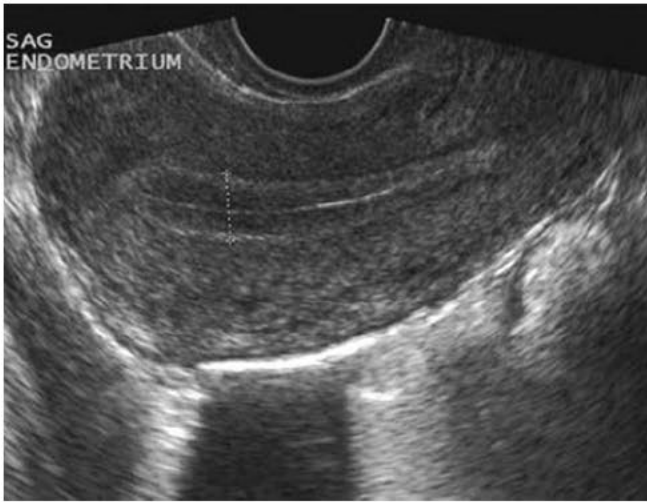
Transvaginal sonogram in the sagittal plane of a characteristic trilaminar proliferative endometrium. Calipers demonstrate proper measurement of the “double-layer” thickness made of the alternating hyper-hypo-hyperechogenic lines.
